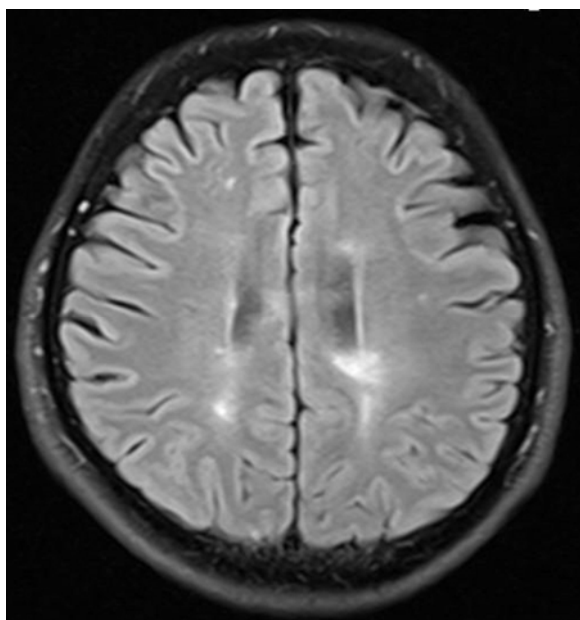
T2 weighted MRI, Hyperintense lesions perpendicular to the lateral ventricles.
